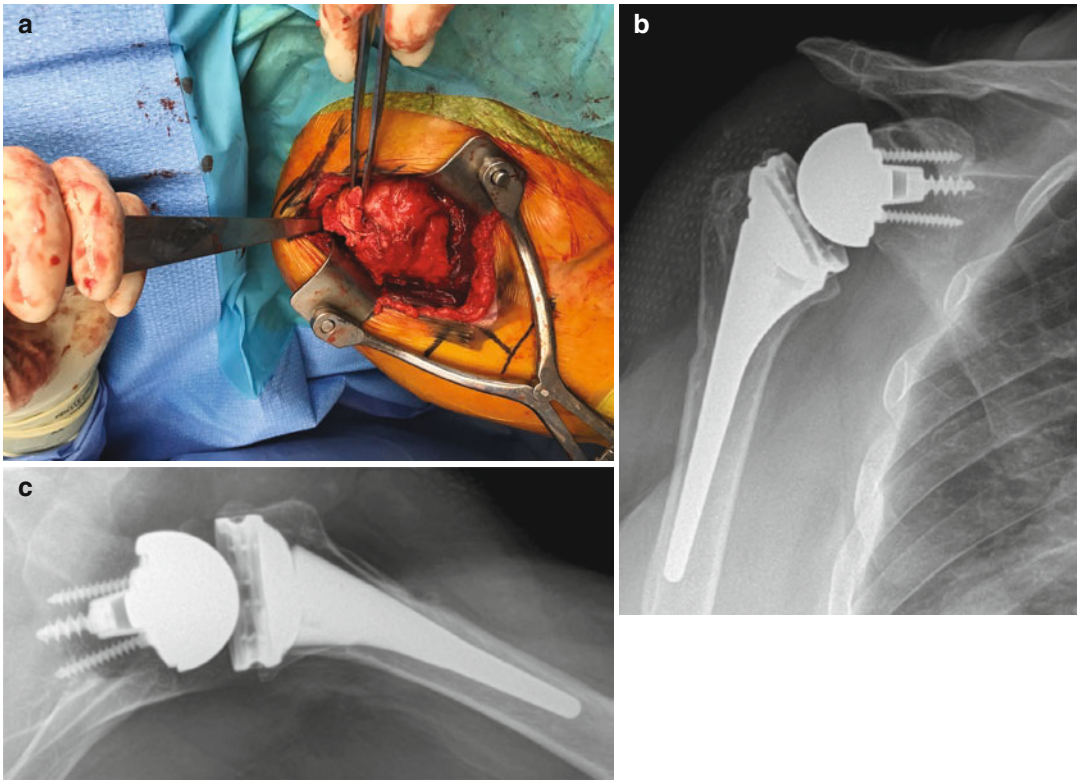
A case with failure of healing of the SCR graft on the humeral side is shown (a). The patient received revision to reverse shoulder arthroplasty as shown on postoperative AP and axillary radiographs (b and c)
